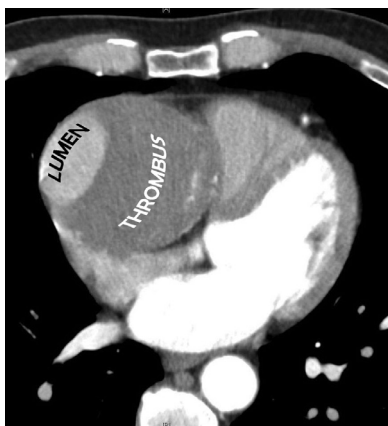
(Case #2, Table 1). Computed tomographic image of the heart showing the coronary aneurysm, both lumen and intra-aneurysmal thrombus.
